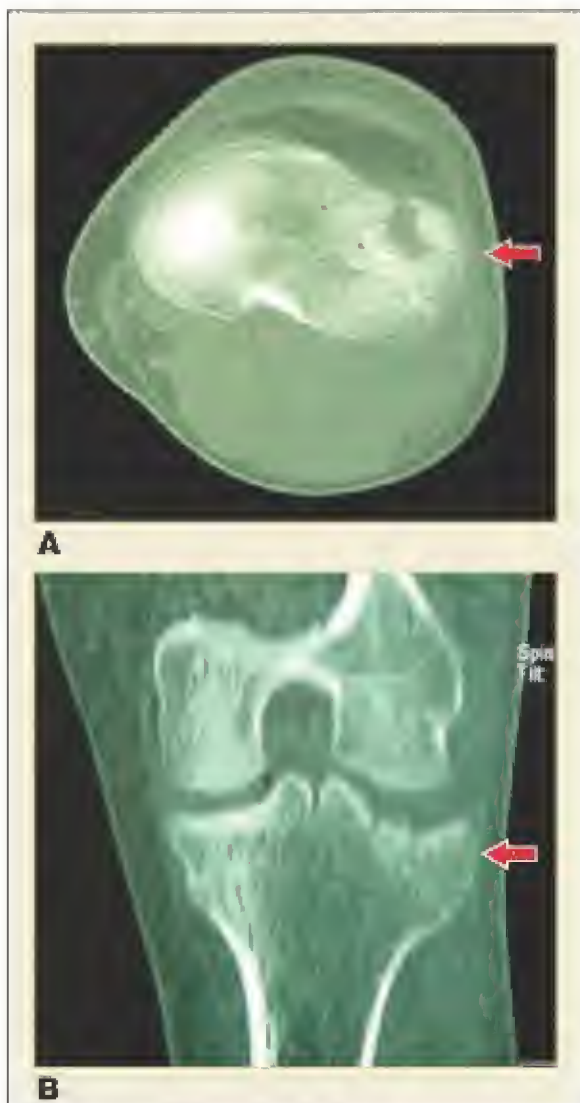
Preoperative axial CT scan (A) of the knee of the same patient reveals displacement of the lateral tibial plateau with depression of the articular surface (arrow). Coronal AP reconstruction CT image (B) shows a decompressed fragment of the lateral tibial plateau (arrow). Surgery was required to restore mechanical alignment.
